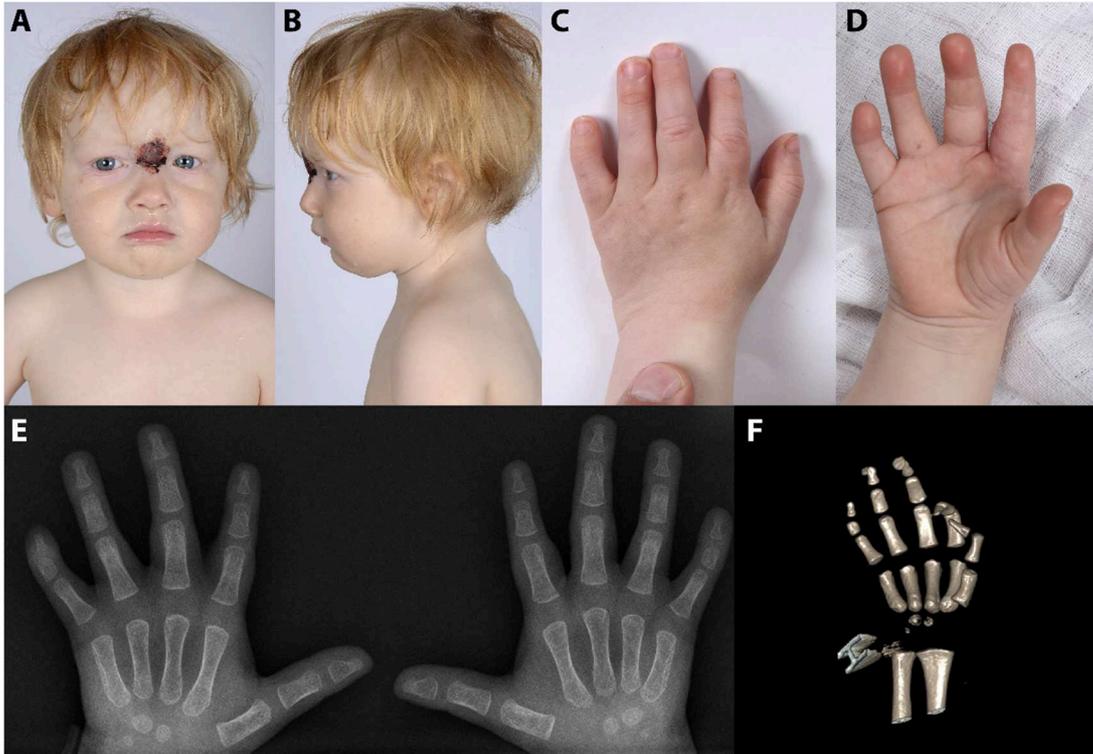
Clinical findings in patient 2. Facial features (A, B), hand malformations with apparent lack of flexion crease at the 4th and 5th PIP joint (C,D) radiographic picture of both hands (E) and 3D reconstruction of the hand obtained in CAT scan (F).
